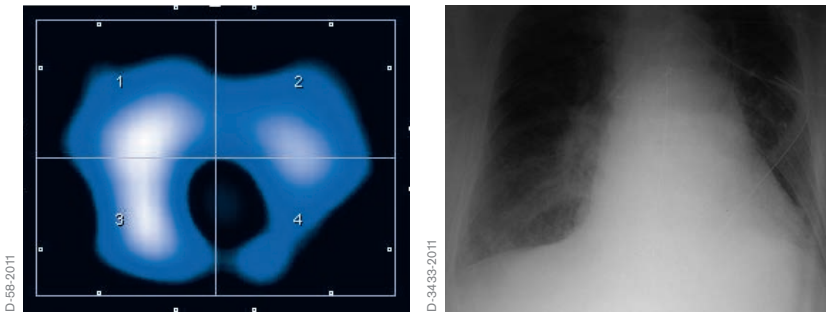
Tidal image and corresponding chest X-ray of a patient with dorsal atelectasis
